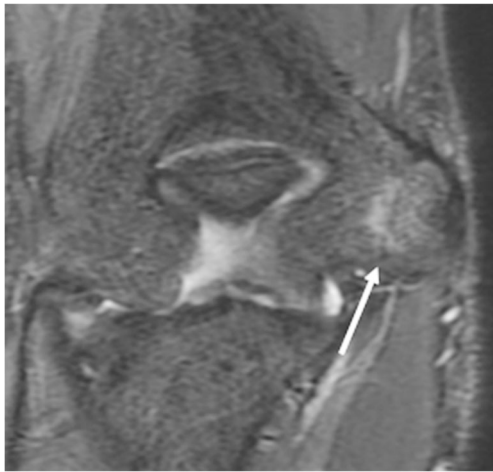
Trochlear pre-ossification center in a 6-year-old girl. Coronal dual-echo steady-state (DESS) gradient MR image demonstrates diffusely increased signal within the small rounded early trochlear ossification center (arrow). This is a normal physiological stage of ossification and should not be mistaken for pathology
